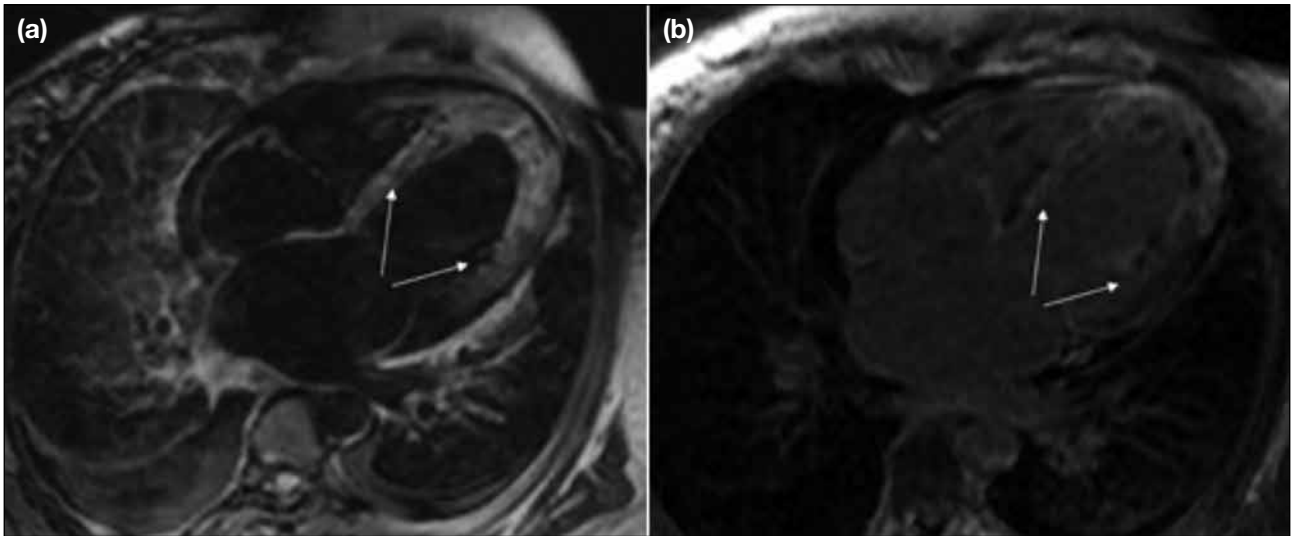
Four-chamber magnetic resonance images at two sequences revealing the left ventricular myocardial infiltration (arrows) in a patient with leukaemia. (a) Four-chamber T2-weighted triple inversion turbo spin echo sequence. (b) Four-chamber phase-sensitive inversion recovery sequence with late gadolinium enhancement.
